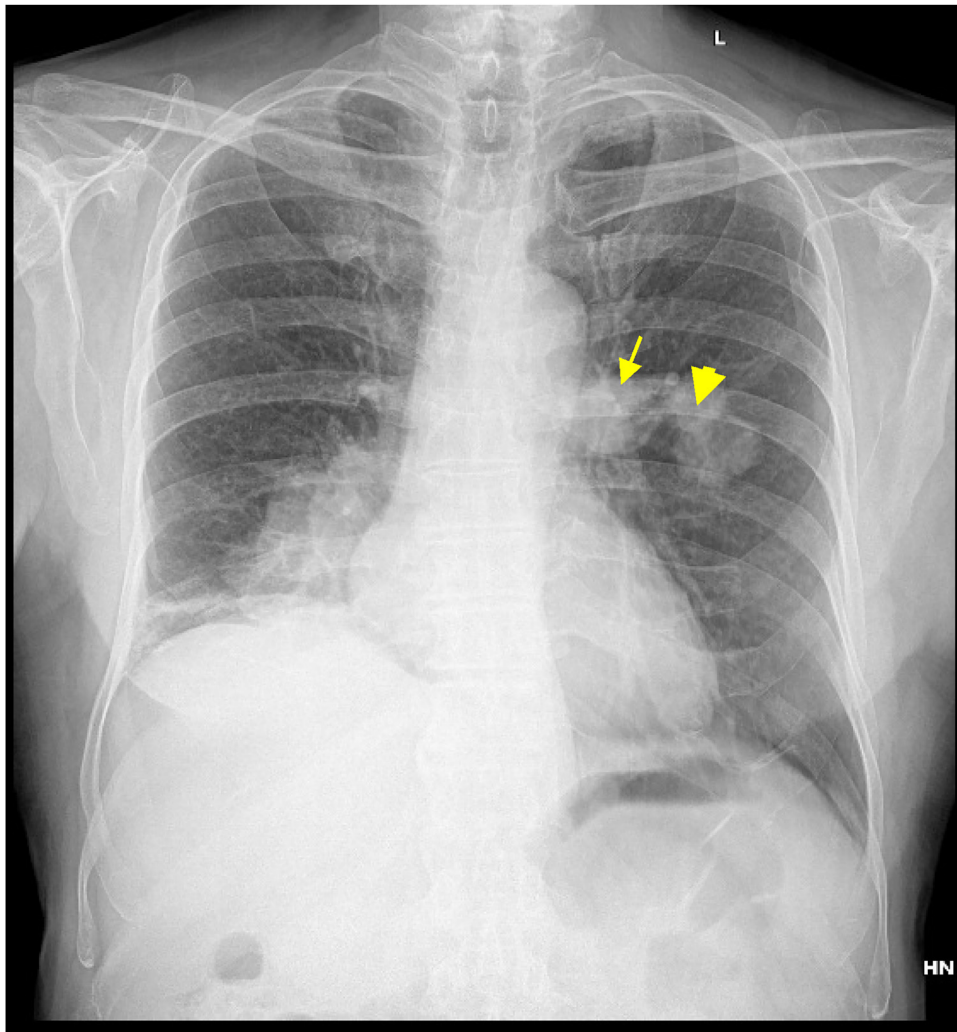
Chest x-ray showing cannon ball metastases.
